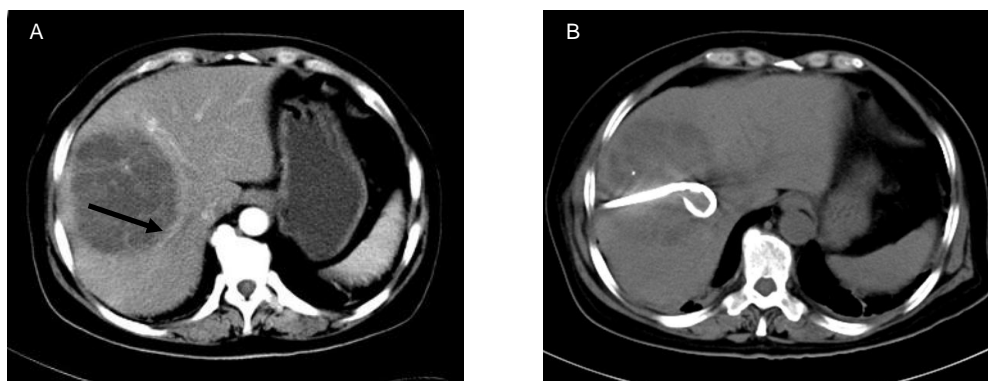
Abdominal computerised tomographic (CT) scans demonstrated an area of abnormal attenuation measuring 84mm × 91 mm in the right lobe of the liver, suggestive of a single large multi-loculated abscess. Figure 1B Emergency CT-guided percutaneous drainage of liver abscess was performed on the night of admission.
